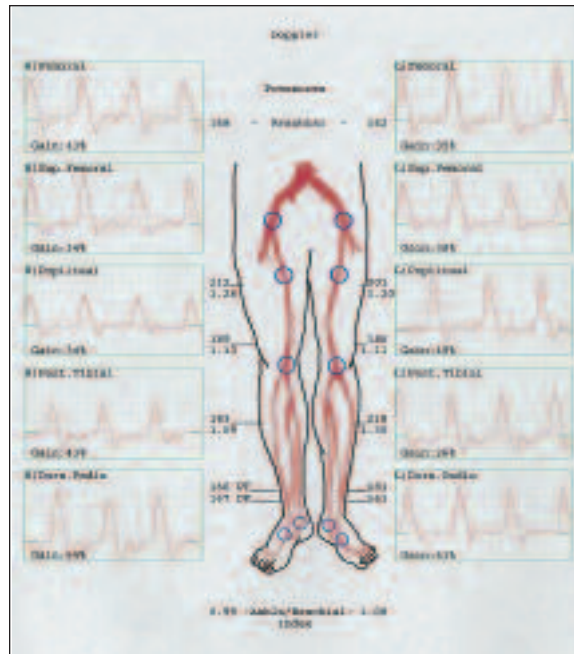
Normal Triphasic Doppler Waveforms.
